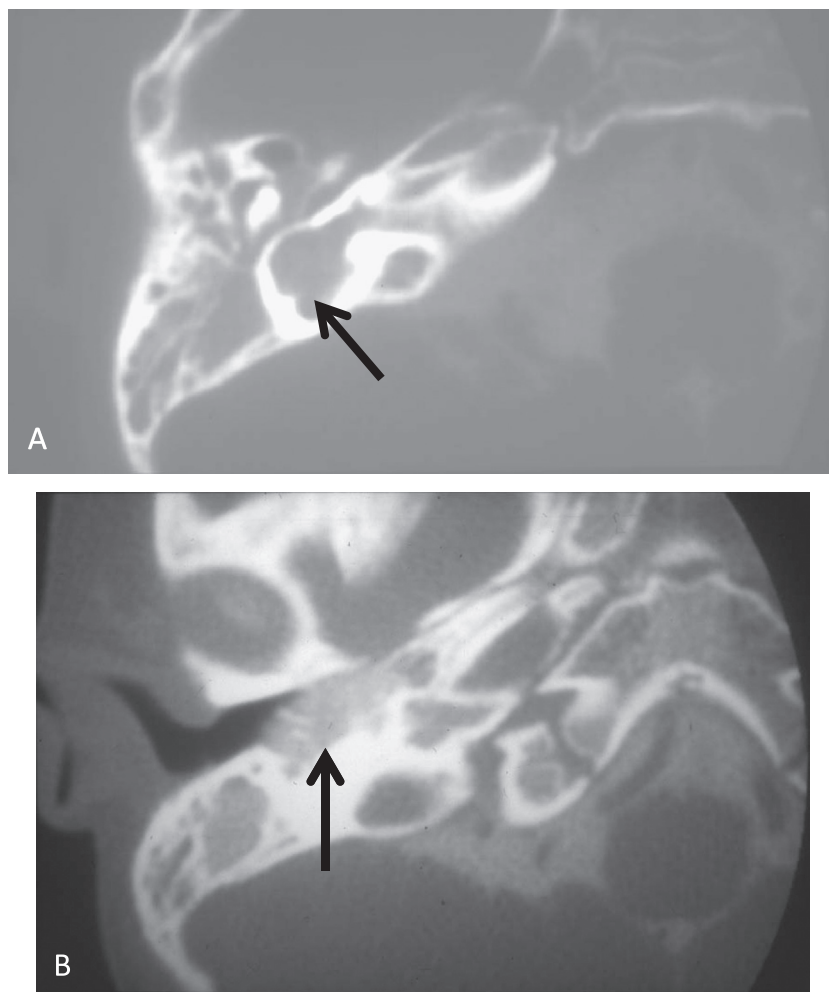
Mondini anomaly. CT positive contrast cisternography showing contrast in the dilated vestibule (arrow in A) and in the middle ear (arrow in B).
